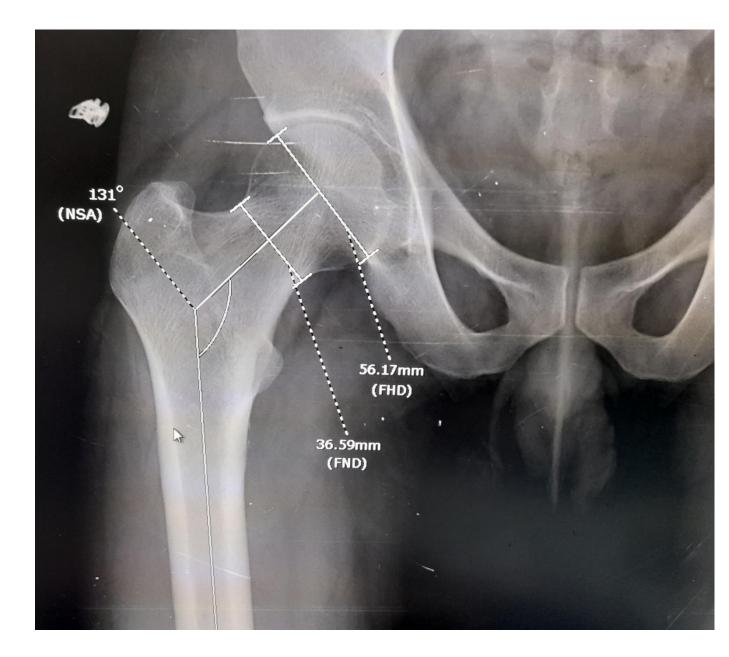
X-ray Hip AP view: Neck shaft angle (NSA) is angle formed by line drawn from femoral shaft axis and line drawn along femoral neck axis passing through center of femoral head. Femoral neck diameter (FND), measured by taking distance in sagittal plane from the middle of neck. Femoral head diameter (FHD), a line drawn perpendicular from center of femoral head.
